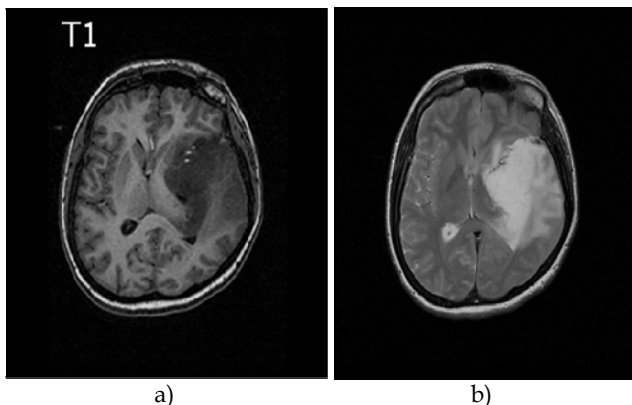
Original MRI images (a) T1 image, (b) T2 image
